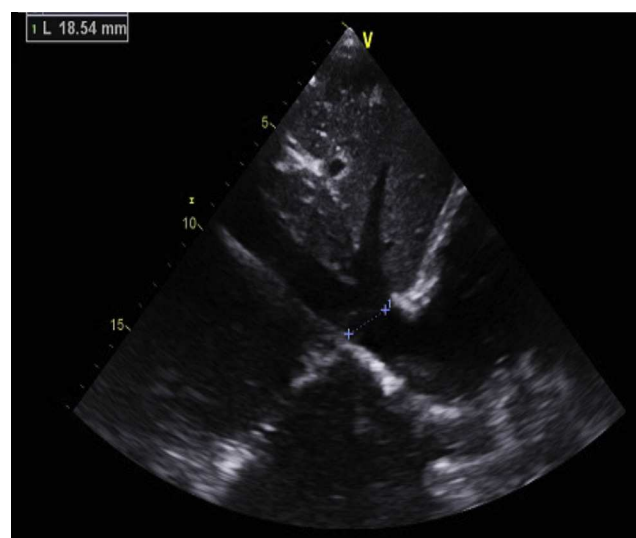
Subcostal echocardiogram view showing a thrombus in the inferior vena cava.
